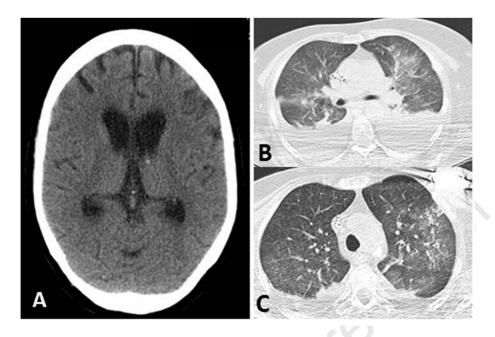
Brain CT Scan demonstrate mild senile cortical atrophy (A); First Lung CT Scan demonstrate bilateral pleural with collapse consolidation of basal segments and patchy ground glass opacities (C); Second Lung CT Scan demonstrate increase in plural effusion amount and ground glass opacities(B).
